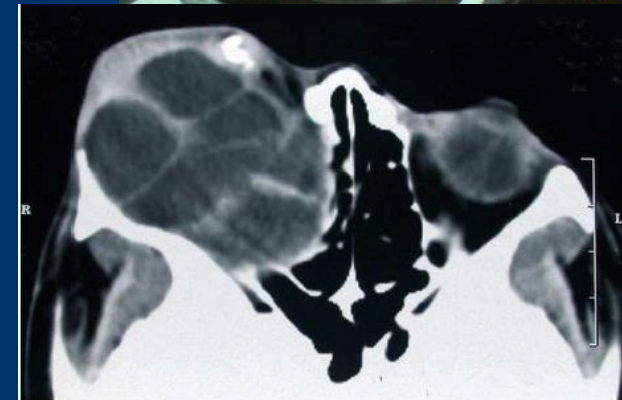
Polycystic echinococcosis in a 14-year-old girl: (Top) Axial computed tomography scan shows closely packed multiple cysts with bony effacement and phthisis bulbi with calcification. (Bottom) Multiple white translucent cysts that have been freshly extracted from the orbit are shown.
